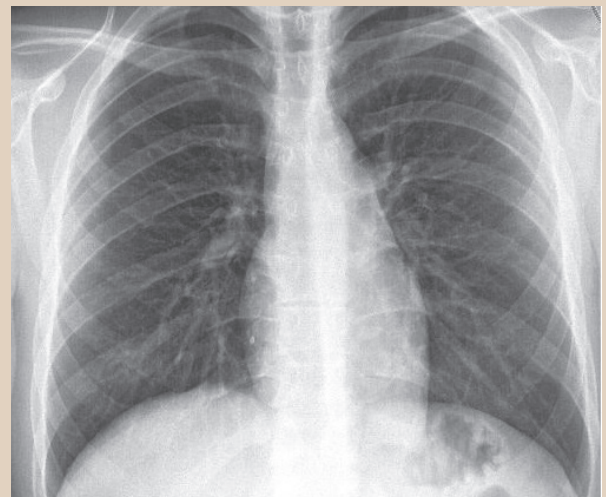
Control chest radiograph after the operation.
